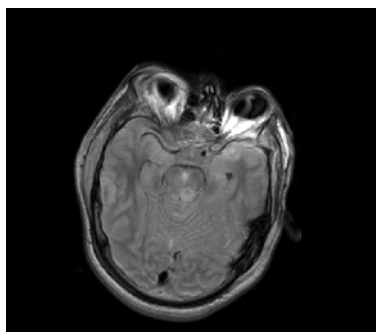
MRI FLAIR showing midbrain contusions.
